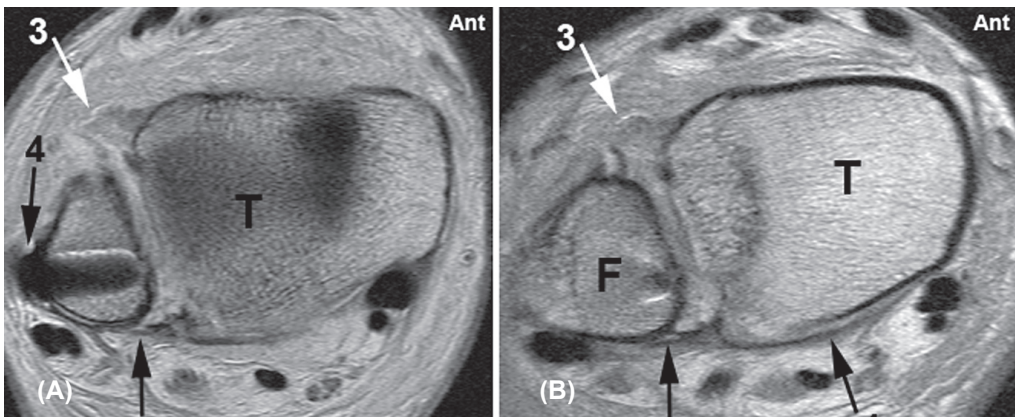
Axial (A) and oblique (B) proton density TSE (turbo spin echo) image. Posterior tibial periosteal slip (1) with a discontinuous PITFL (2) in the axial plane (A) and an intact PTIFL in the oblique plane (B). In both planes the ATIFL (3) is ruptured. Although there is a screw present in the fibula (4), the quality of the MR image is still good and the tibiofibular ligaments can be well evaluated. T, tibia; F, fibula; Ant, anterior.
